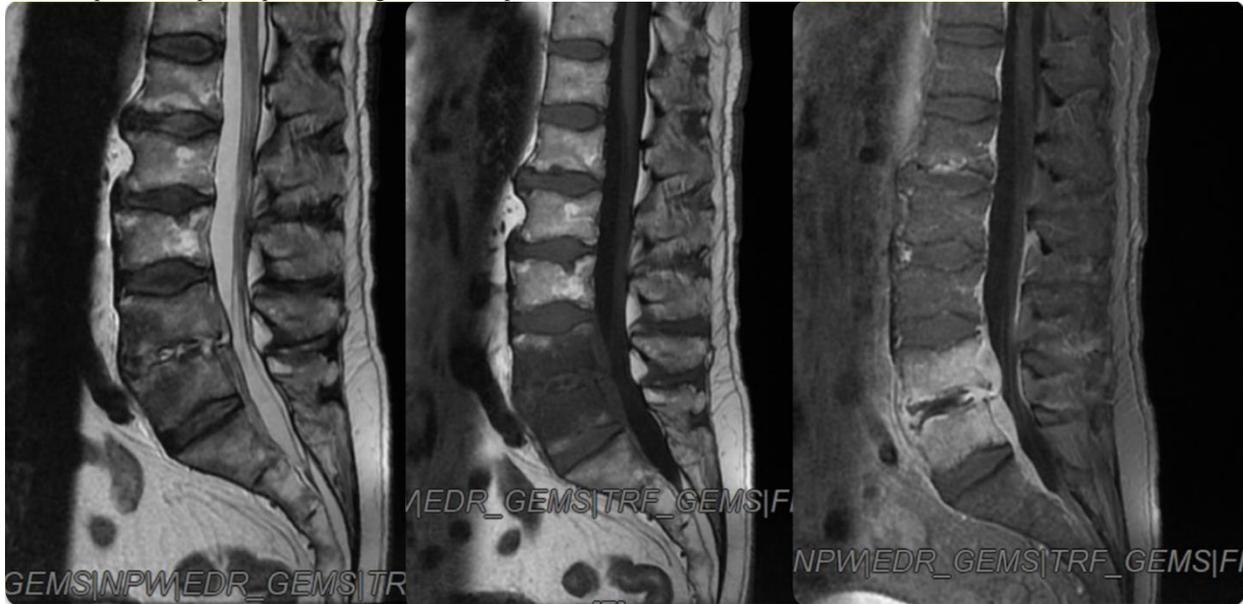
A. MRI T2 sequence, no iv contrast- minimal hyperintense signal in the upper side of the previous posterior epidural collection at L2-L3 level and anterior epidural collection L3.
